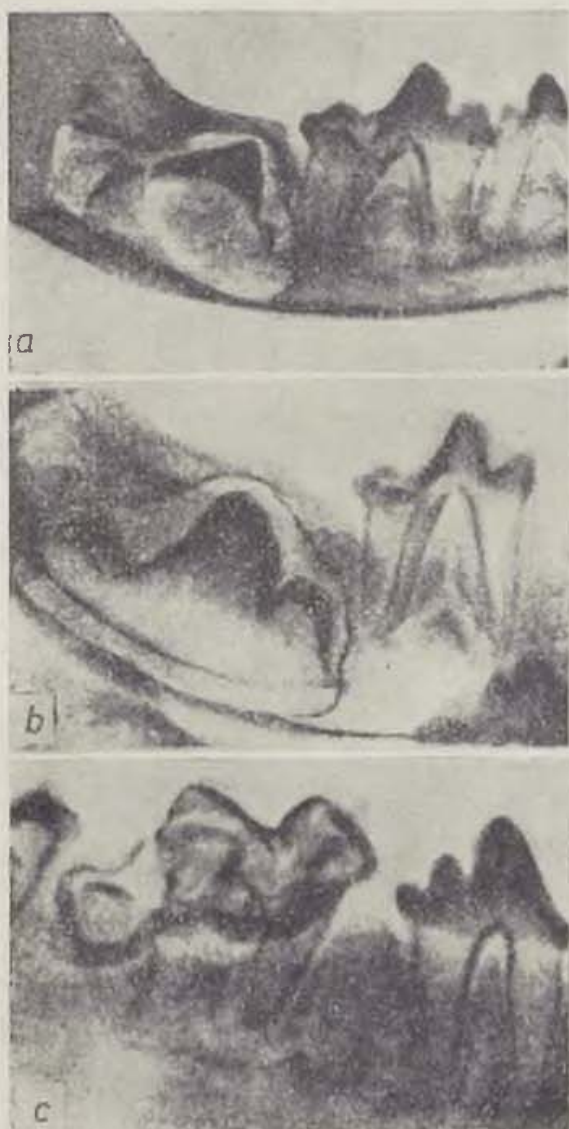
Roentgenographic study of dental anlage transplantation. a) seven days after transplantation of anlage; b) 30 days after; c) six months after
